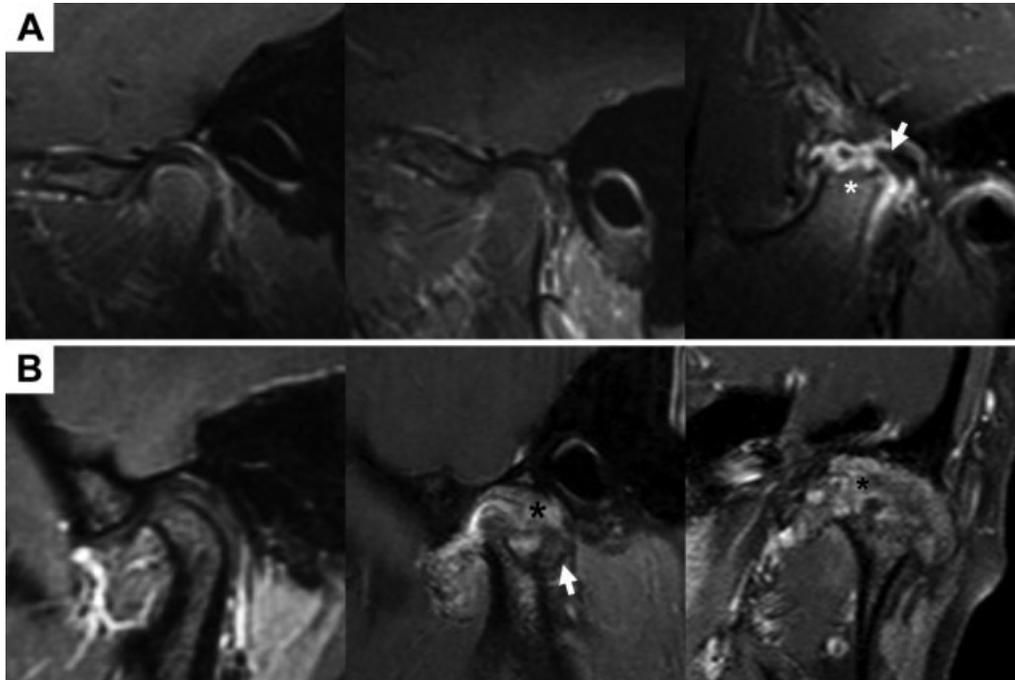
Temporal progression of temporomandibular joint arthritis. A, Sagittal T1 fat-suppressed (FS) with-contrast (C+) images of the same patient obtained in 2010 (left), 2011 (middle), and 2012 (right). Only mild synovial enhancement was present in 2010. In 2011, after systemic methotrexate and etanercept therapy, enhancement had decreased. The patient was subsequently lost to followup with no treatment, and in 2012 magnetic resonance imaging showed severe synovial enhancement, cortical irregularity, subarticular erosions (*), and disc destruction with displacement (arrow). B, Sagittal T1 FS C+ image obtained in 2011 (left) and sagittal (middle) and coronal (right) T1 FS C+ images of the same patient obtained in 2011. Only mild synovial enhancement was present in 2011. By 2012, severe synovial thickening and pannus (*) had developed, along with extensive destructive osseous changes with fragmentation (arrow).
